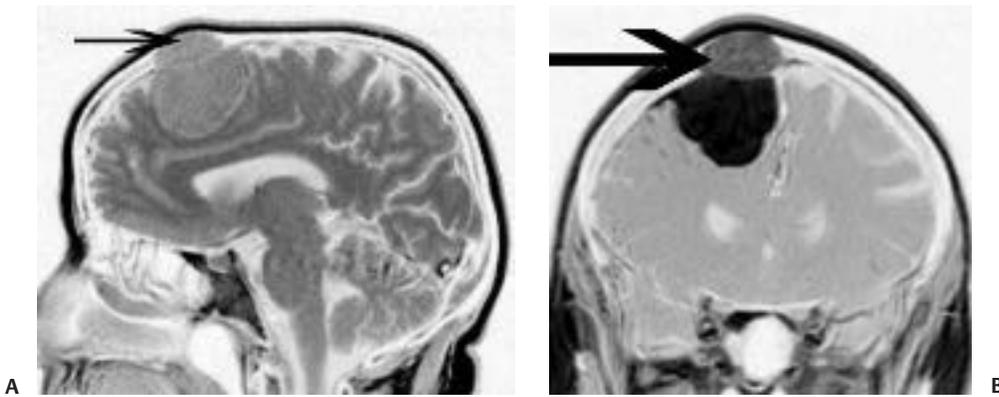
(A) Sagittal T1 noncontrast and (B) coronal T1 magnetic resonance image after gadolinium administration demonstrate invasion of the calvarium by this atypical (World Health Organization grade II) meningioma.
